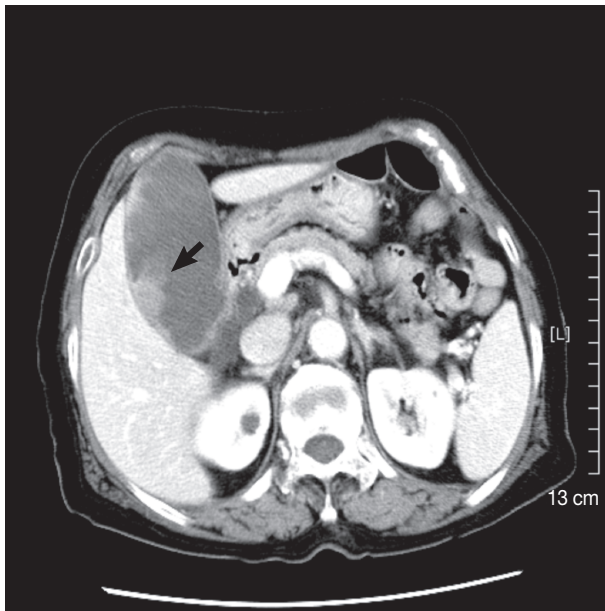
The computed tomographic scan shows an intraluminal polyphoid mass (arrow) with irregular wall thickening of the gallbladder.
